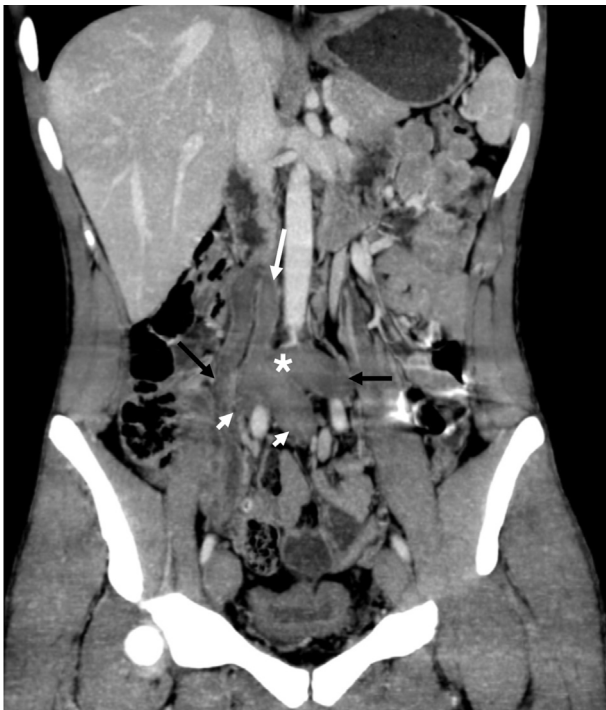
Computed tomography angiography, coronal reconstruction, shows a confluent inferior vena cava stump (asterisk), dilated gonadal vein (right black arrow), dilated lumbar vein (left black arrow) and iliac veins (white arrowheads), and thrombosed right gonadal vein (long white arrow).
